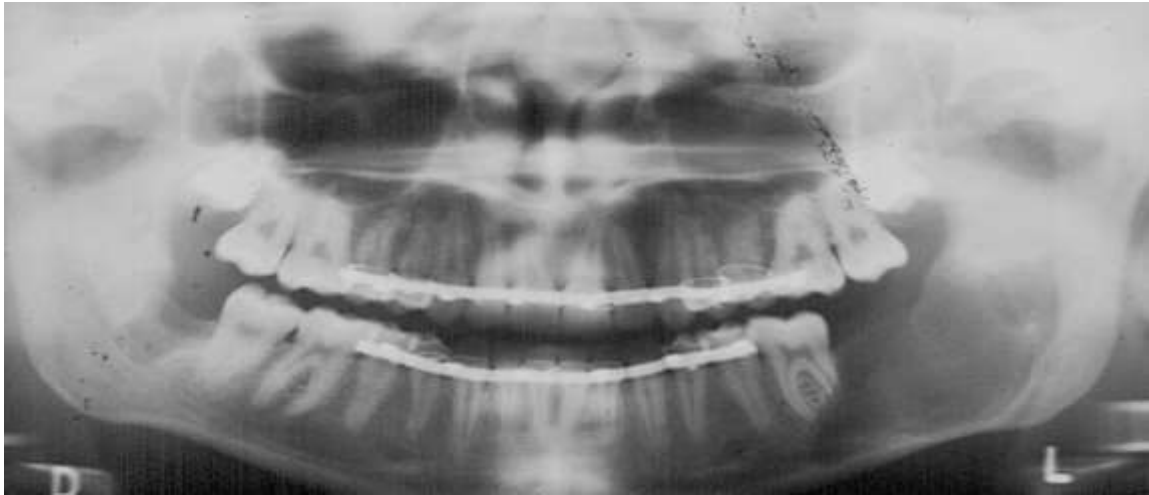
b- postoperative panoramic radiograph at one month.
